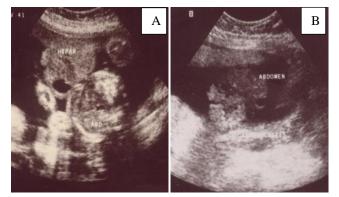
USG of pregnancy: ultrasound appearance of omphalocele (A) and gastroschisis (B) at 18-19 weeks of gestation
